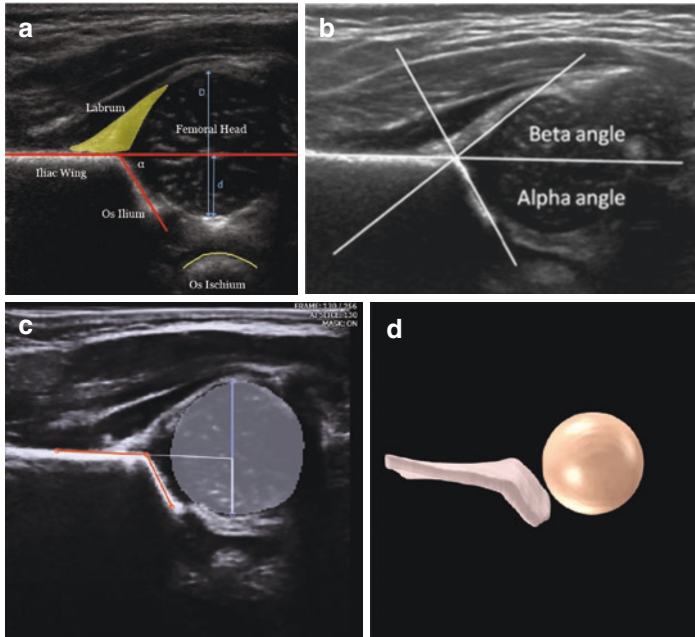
(a) Coronal ultrasound image in the “Graf standard plane” through the mid-hip joint with flat iliac wing, round femoral head, os ilium and os ischium visible, showing the measurement of the Graf α angle and acetabular coverage (d/D) and (b) Graf α (alpha) and β (beta) angles. (c) Automated identification of acetabulum and femoral head (segmentation) by artificial intelligence from 3D ultrasound, with (d) the corresponding 3D shape model. (Credit: Medo.ai)
